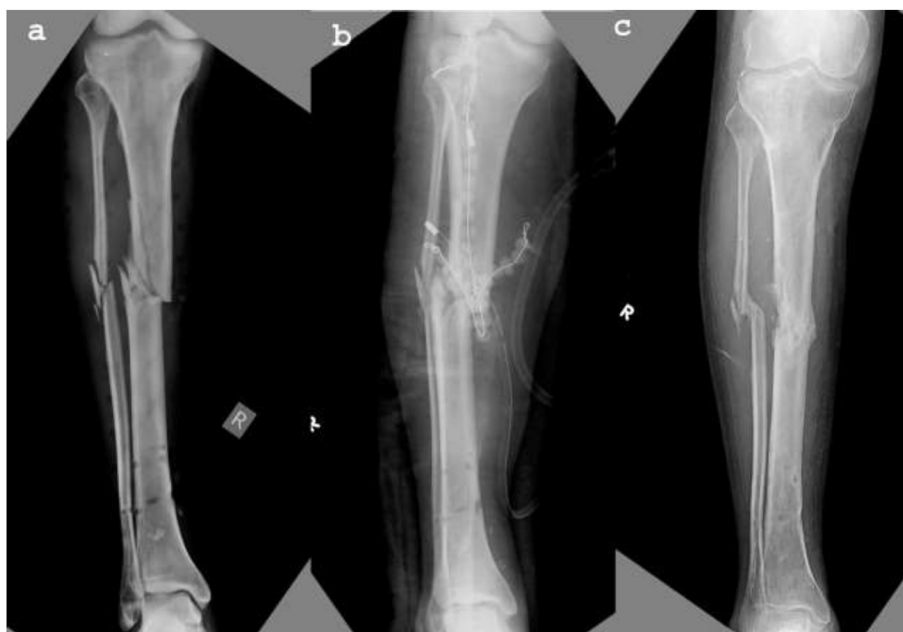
Anteroposterior radiographs of a case treated for infected open fracture of the tibia (a: preoperative, b: postoperative, and c: follow-up at 1 year).
